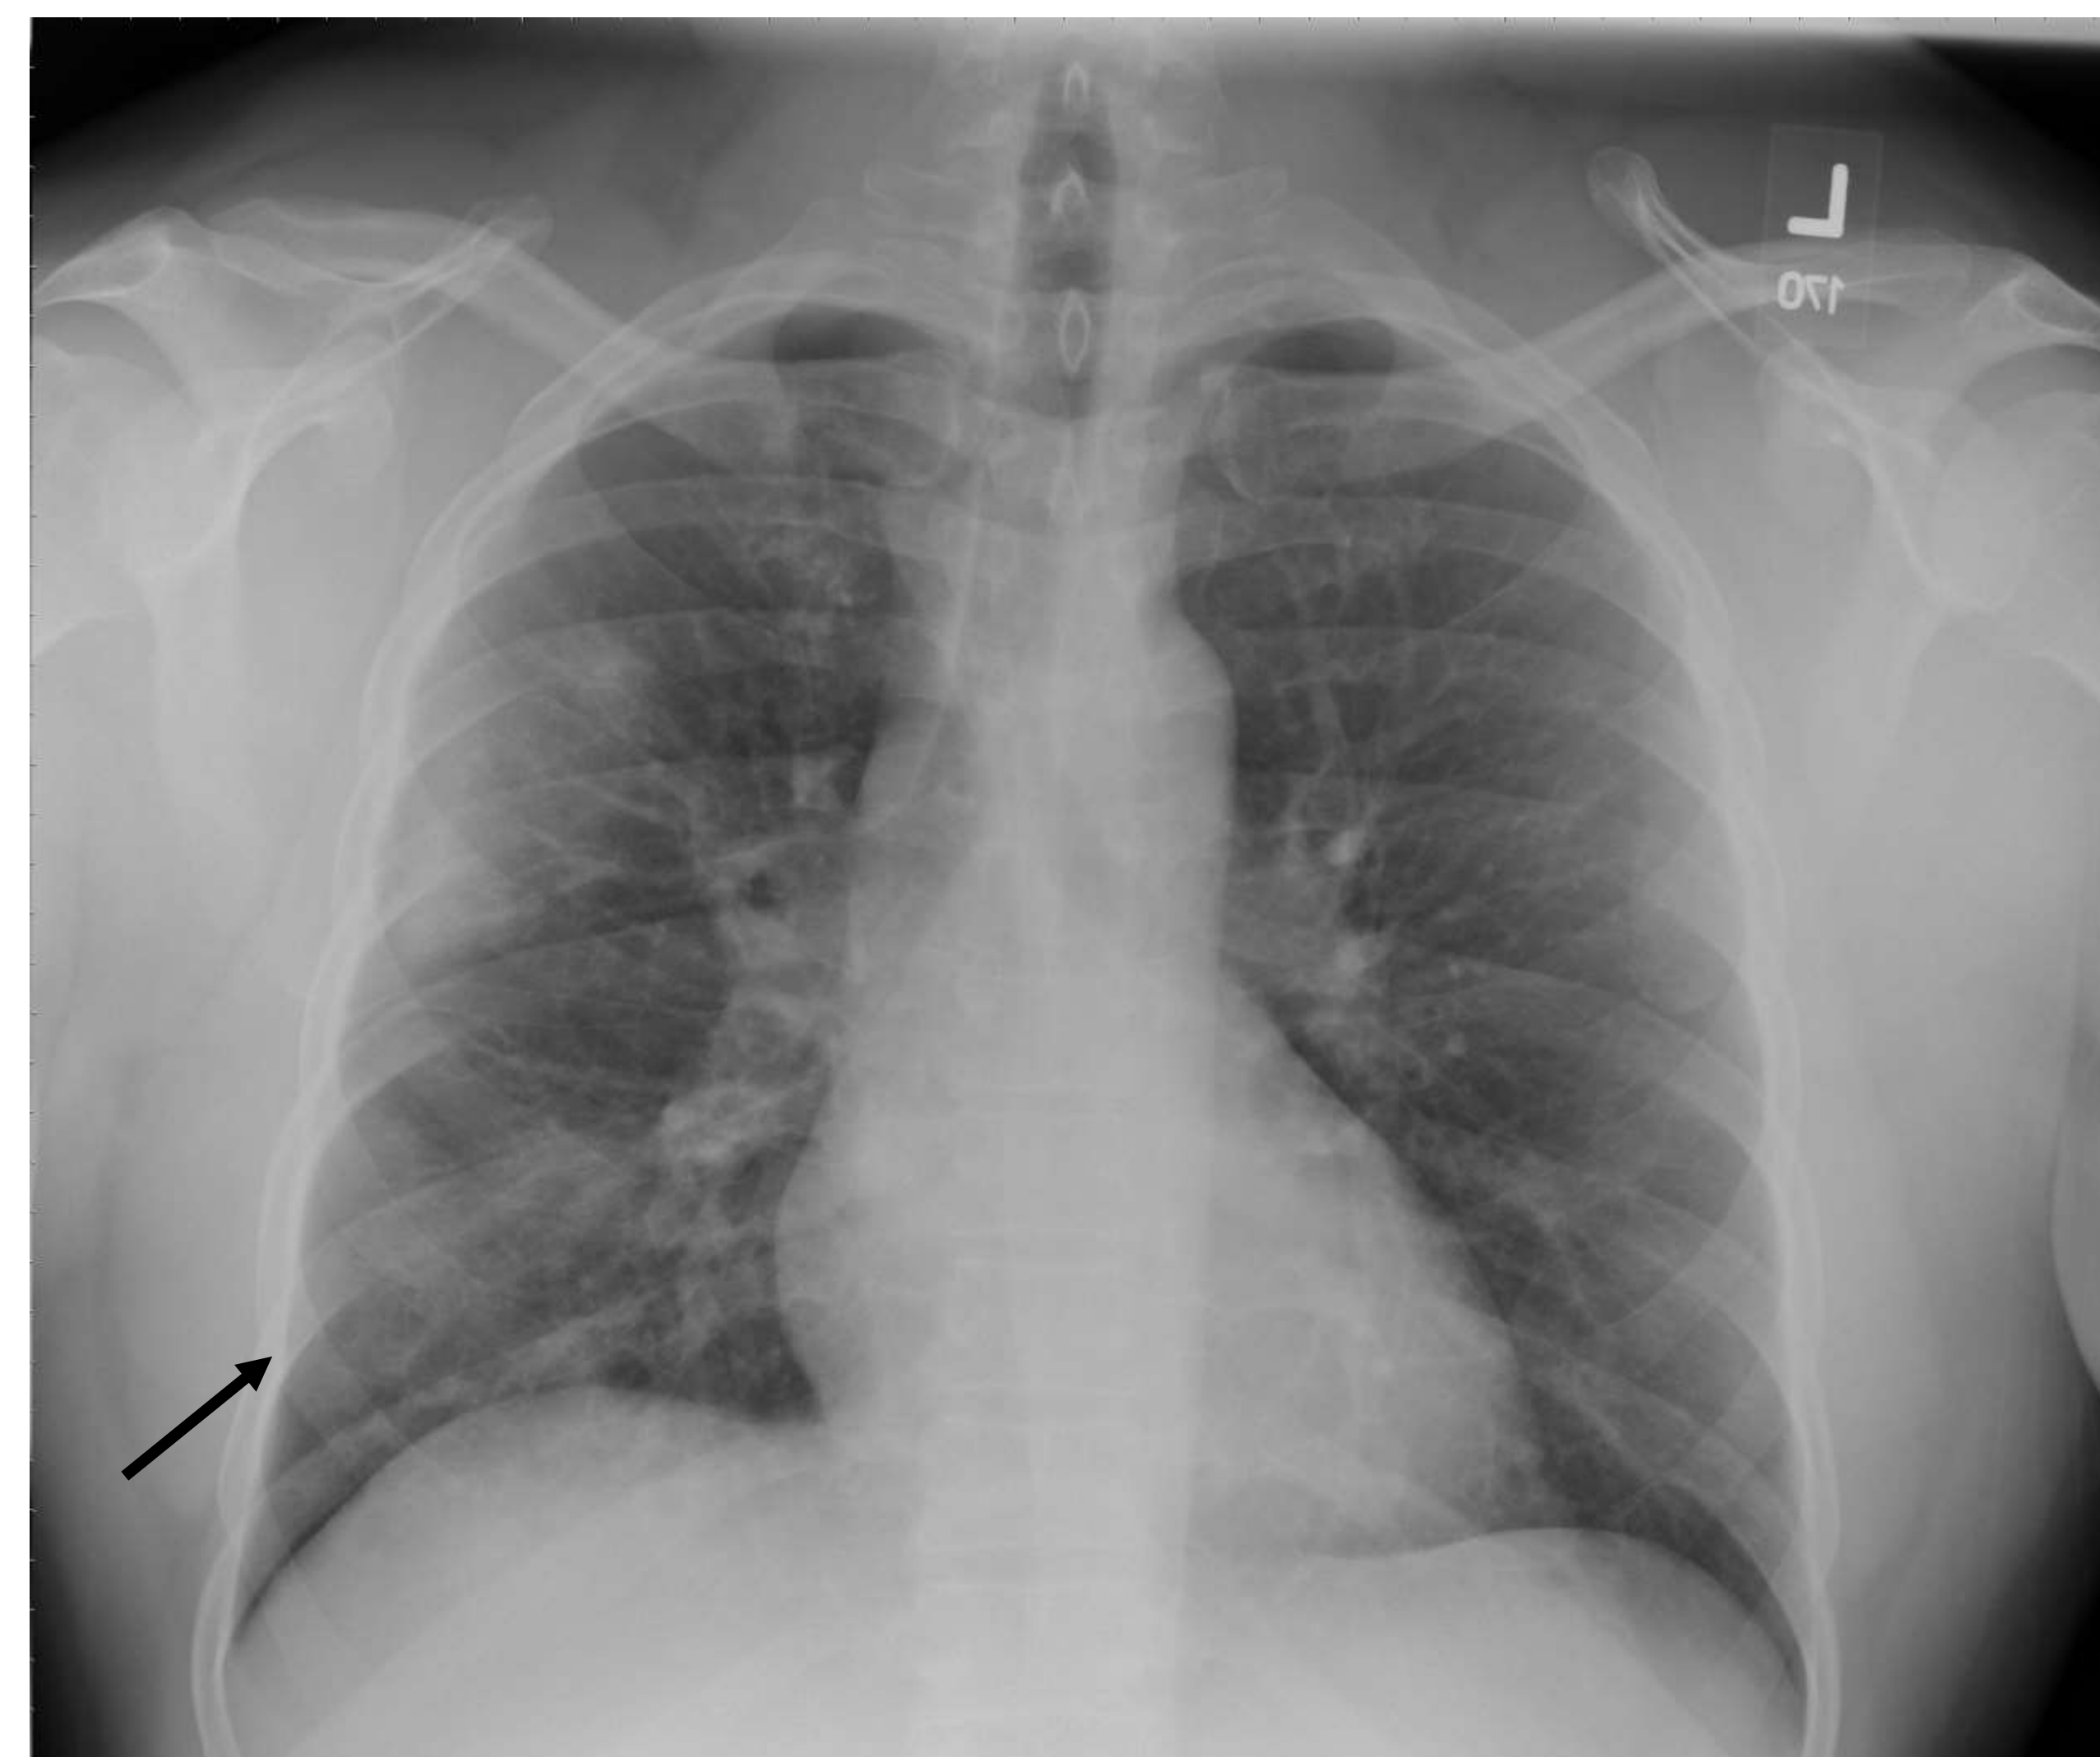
Chest x-ray of the patient
